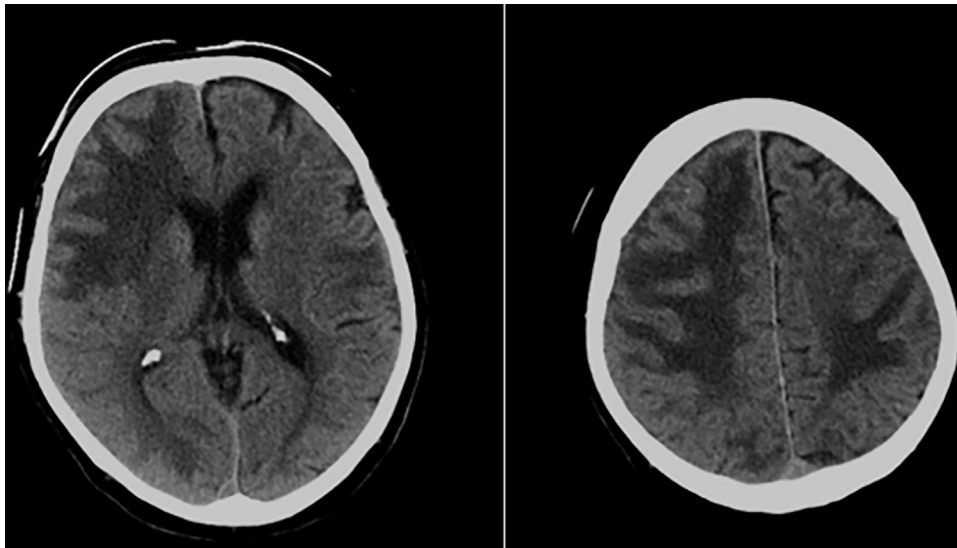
Brain CT scan on first admission.
